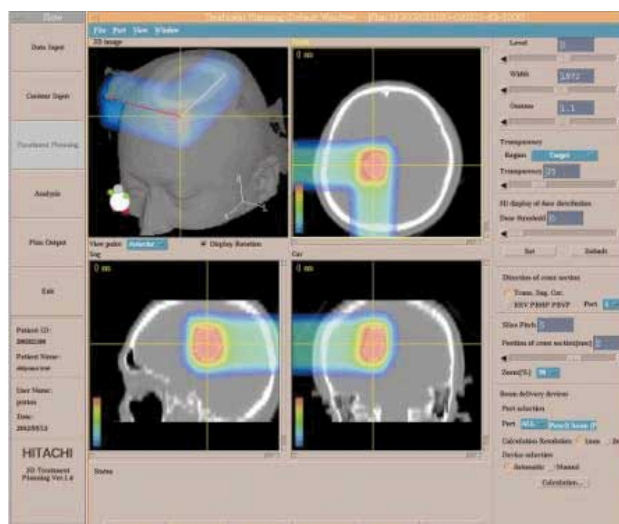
Screenshot of Proton Beam Therapy Planning System. This example shows the calculation of the dose distribution for two-port irradiation of the head. The dose distribution is shown superimposed on CT scans. A large dose is delivered to a region inside the patient's head, showing that it is possible to concentrate the irradiation on a target.
